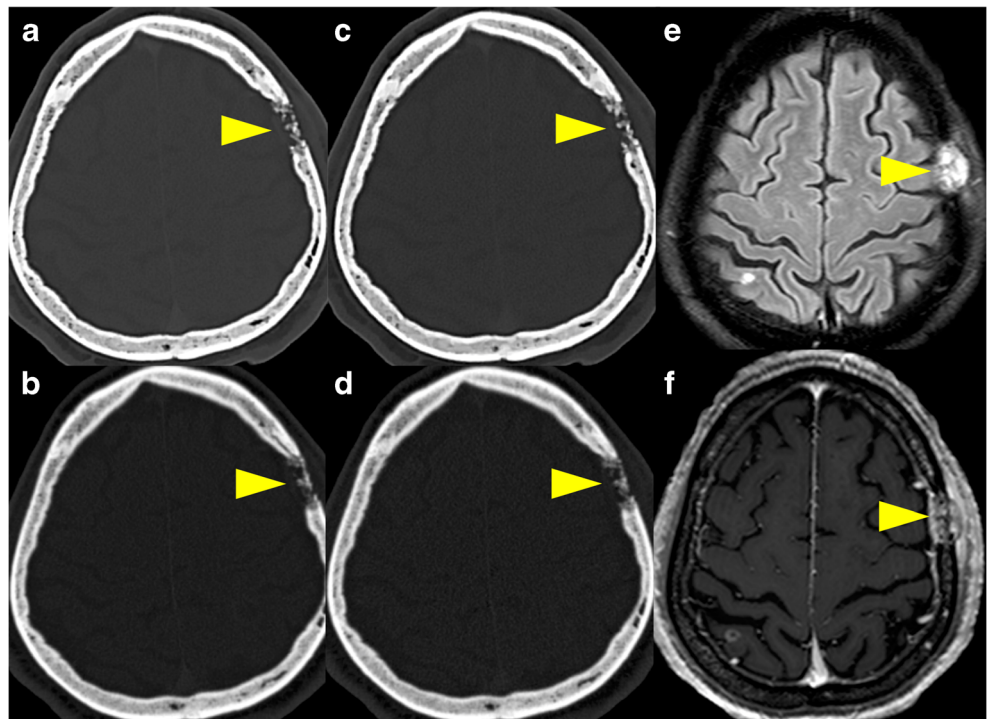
Bone lesion. Left frontal bone lesion correctly detected by all CT techniques (arrow head)
